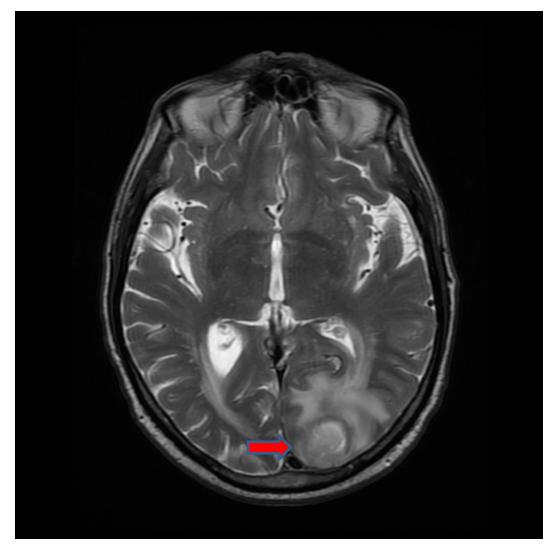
A well-defined, rounded area measuring 2cm x 3 cm in the left occipital lobe seen on MRI.
